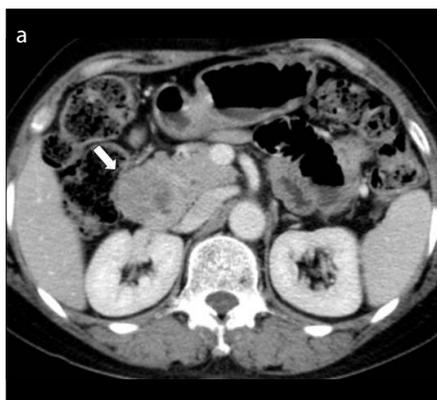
a, b. CT and EUS images in a 59-year-old woman with large duodenal GIST. Arterial phase axial image (a) and arterial phase coronal image of contrast-enhanced CT shows a 4.0 cm well-defined lobulated, heterogeneous enhancing mass (arrow) at anterolateral wall of the second part of the duodenum invading the pancreas head. Note the central hypodense portion within the mass suggesting central necrosis. She underwent EUS (b) to reveal a bulge in the second part of the duodenum, which showed a heterogeneous hypoechoic lesion with irregular margins, originating in muscularis propria. It was proven to be a duodenal GIST in biopsy.
